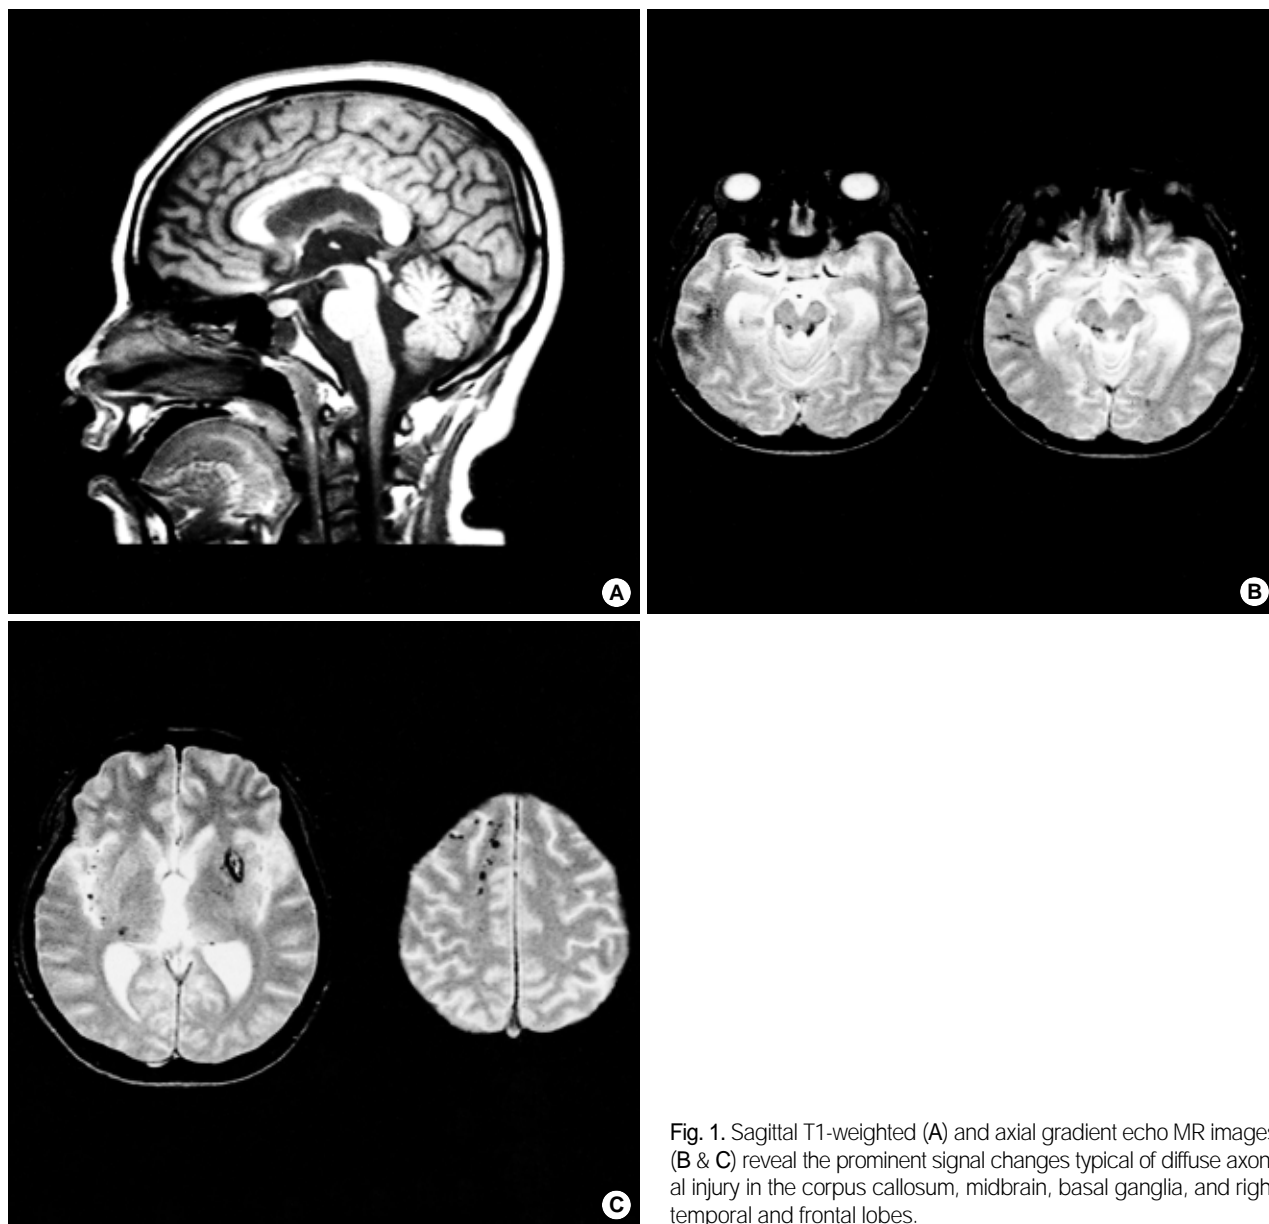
Sagittal T1-weighted (A) and axial gradient echo MR images (B & C) reveal the prominent signal changes typical of diffuse axonal injury in the corpus callosum, midbrain, basal ganglia, and right temporal and frontal lobes.
